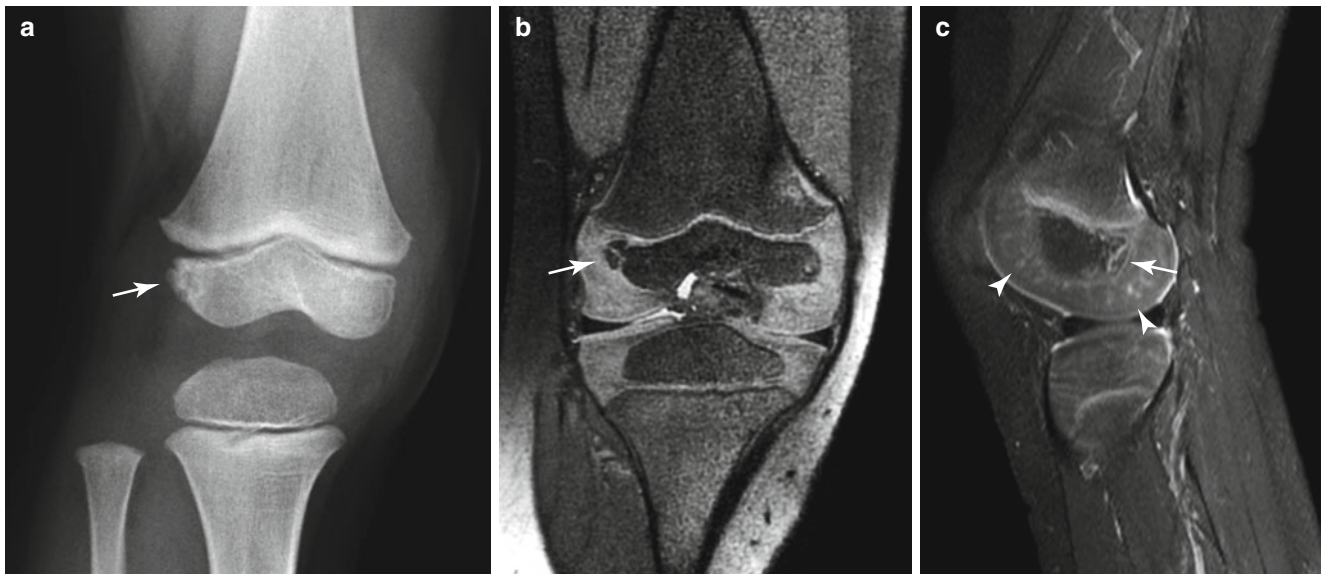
Irregularity of distal femoral epiphysis* (a) Anteroposterior radiograph of the right knee shows a marginal irregularity (*arrow*) at the lateral epiphysis of the distal femur. (b, c) Coronal proton density fat-suppression VISTA image (b) and sagittal contrast-enhanced T1-weighted image (c) show cortical irregularity and fragmentation
